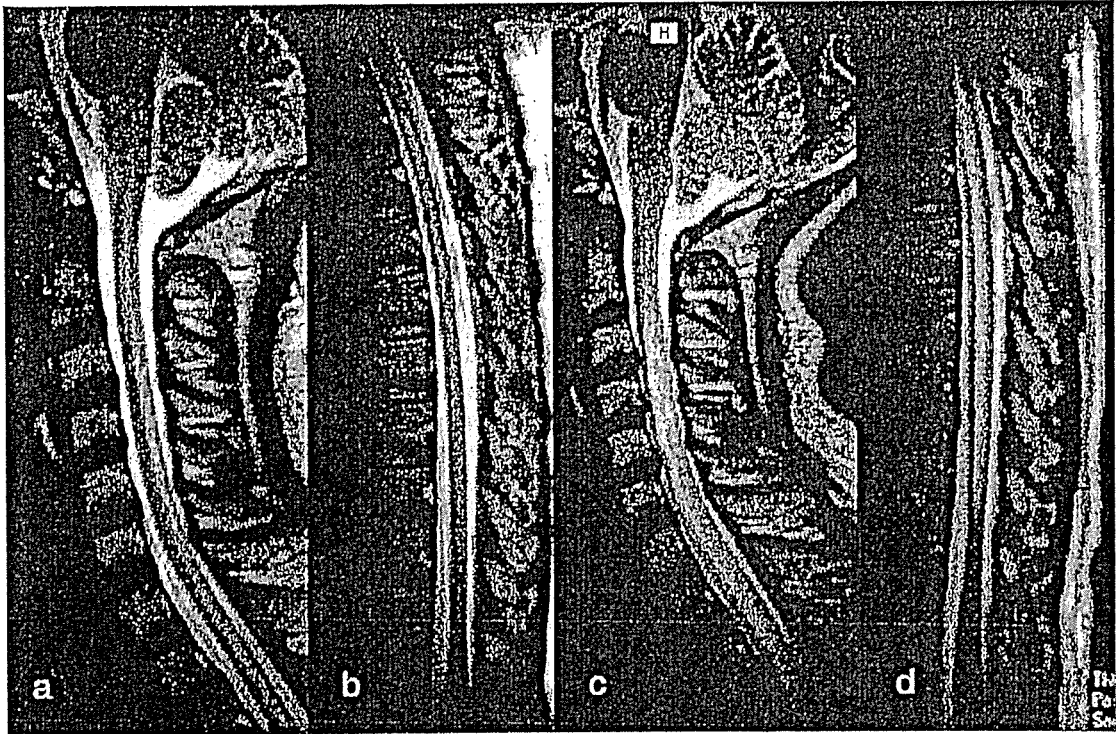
Follow-up MRI after treatment (patient 1). (a) Sagittal T2WI shows improvement but still residual high-signal intensity in the posterior aspects of the cervical cord. (b) Sagittal T2WI showing disappearance of the high signal intensity area in the thoracic cord. (c, d) On relapse, sagittal T2WI showing swelling with high intensity signal throughout the spinal cord.
